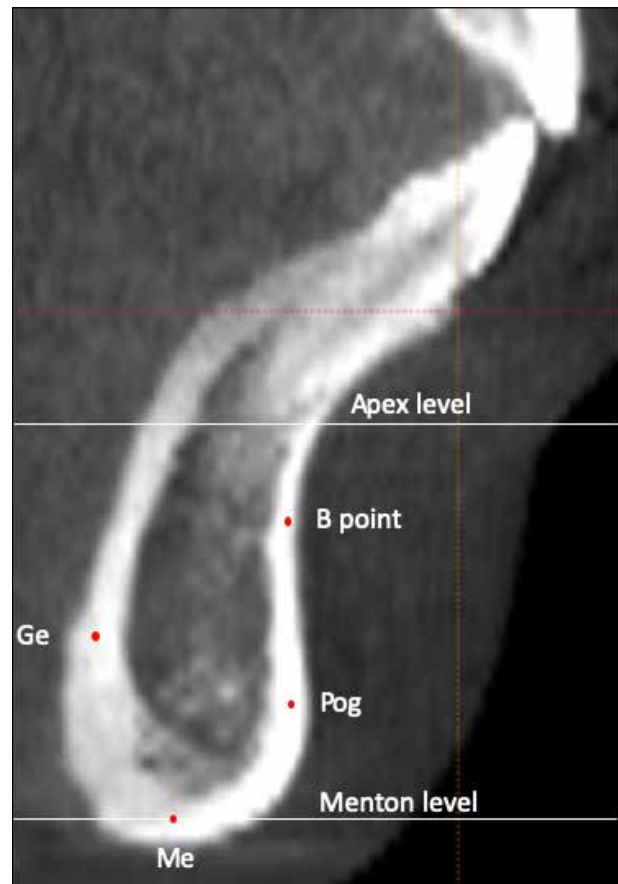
Locations for symphysis bone density measurements on a mid-sagittal slice of C-mode CBCT image: genion (Ge); menton (Me); pogonion (Pog); B point.
